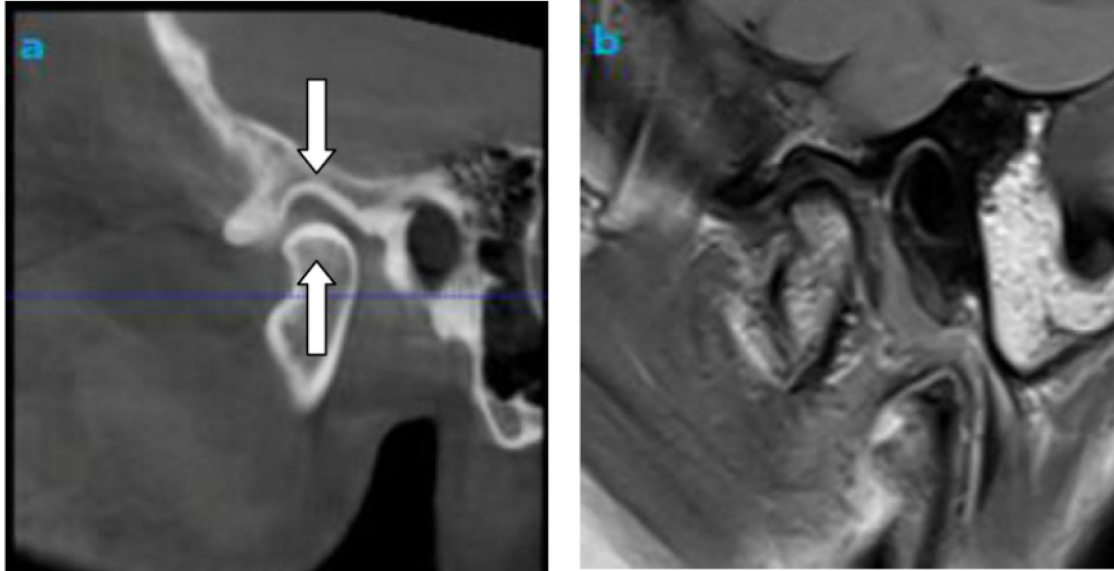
A 40-year-old woman with chief complain of bilateral TMJ clicking and limited mouth opening. (a) The cone beam CT image revealed sclerosis of the right condylar head and temporal fossa (arrows); whereas, (b) sclerosis was evident only in the temporal fossa and not clear in the condylar head on the sagittal proton density-weighted (arrow)
